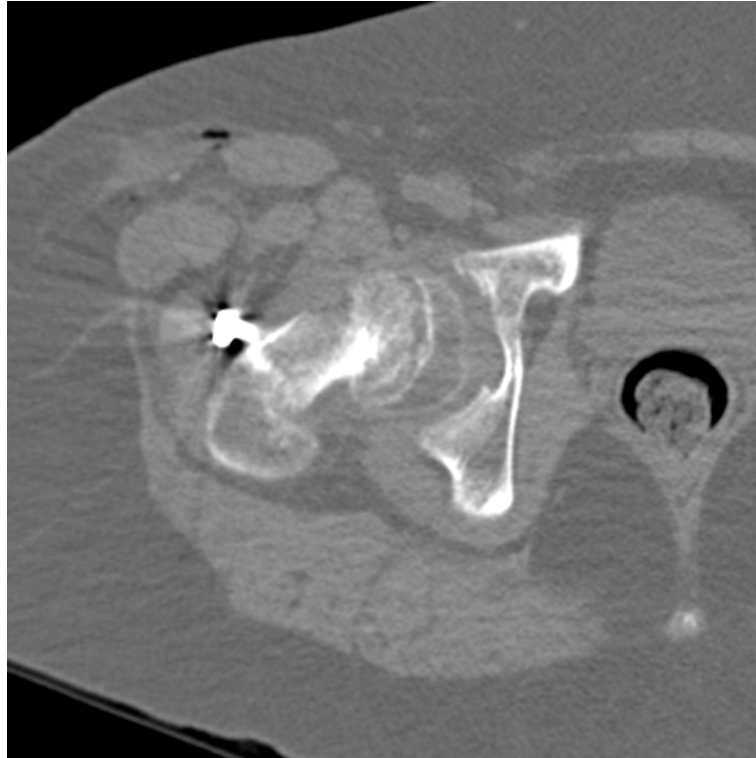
Axial CT through physis demonstrating convexity and scalloping.
